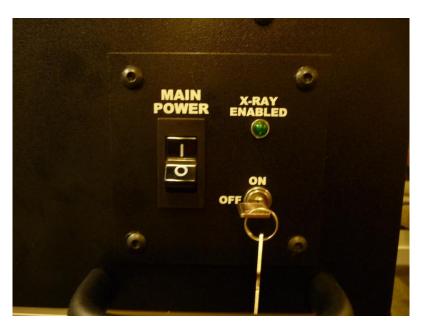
TruView Main Power/X-Ray Enable Pane
